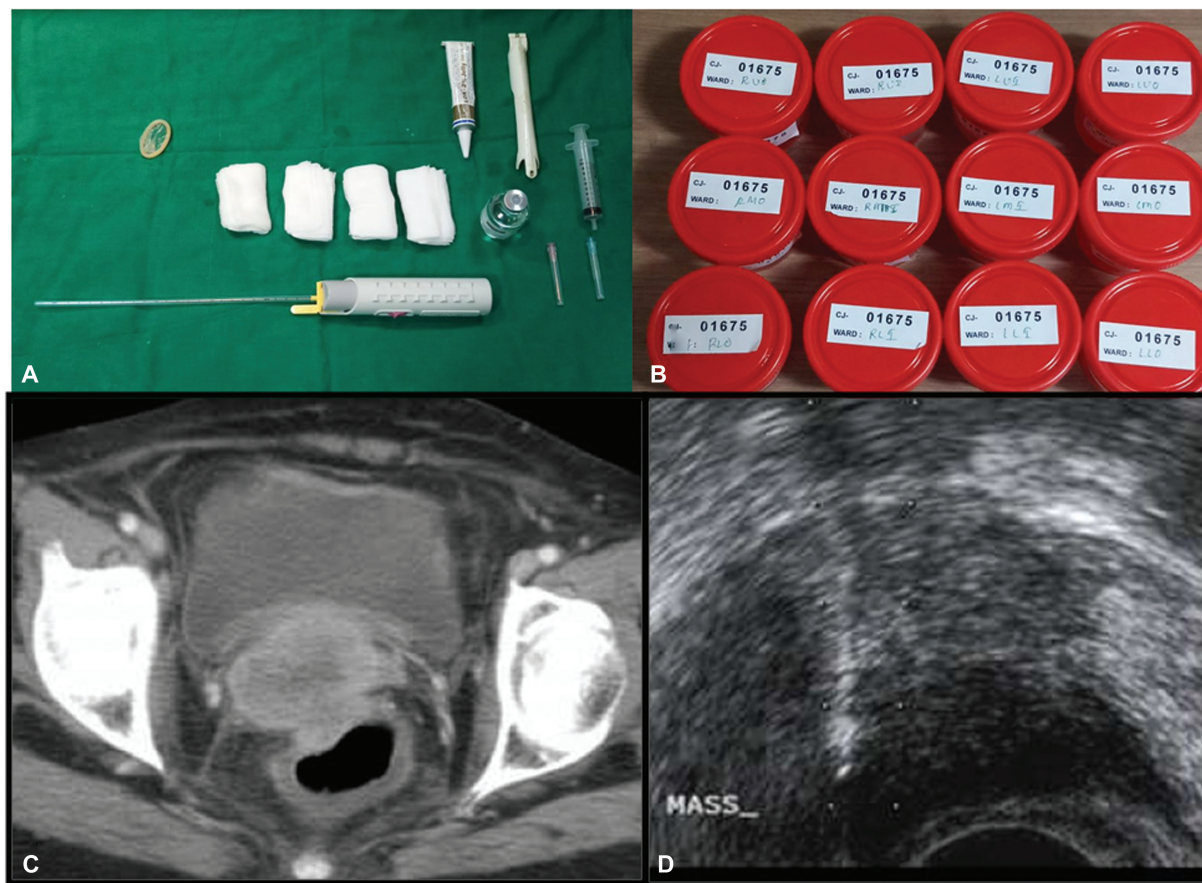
(A-B) Instrumentation used in TRUS guided biopsy and 12 containers for 12 core biopsy of the prostate. (C-D) Axial CT shows an ill-defined cervical mass sampled through TRUS guided approach.
